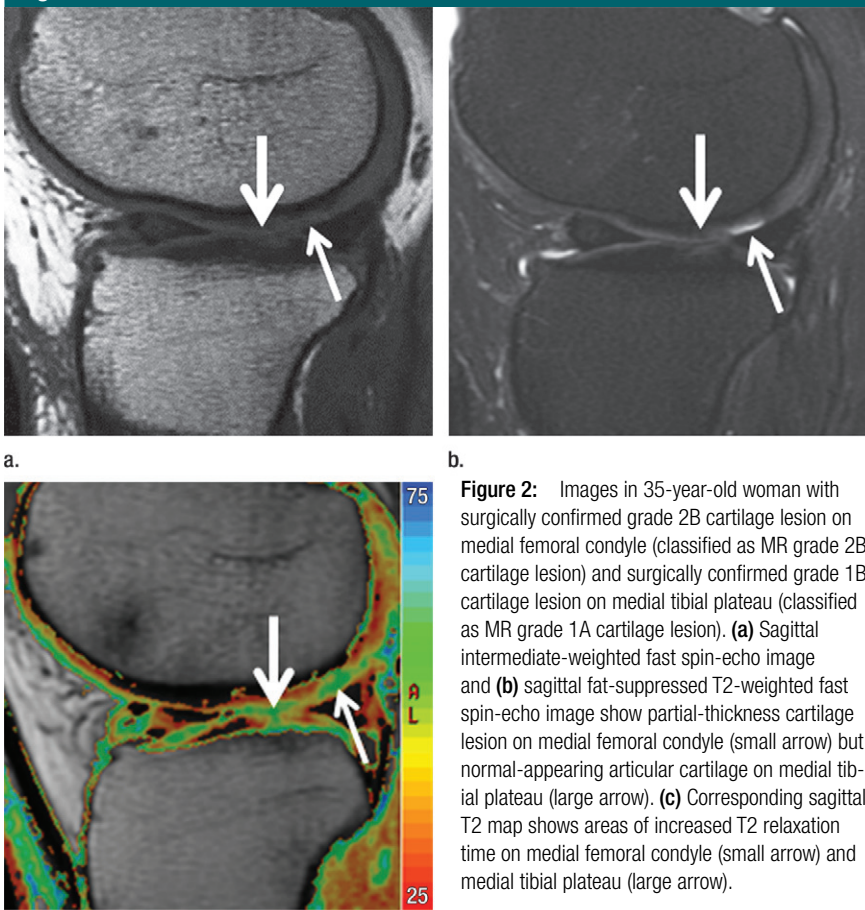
Images in 35-year-old woman with surgically confirmed grade 2B cartilage lesion on medial femoral condyle (classified as MR grade 2B cartilage lesion) and surgically confirmed grade 1B cartilage lesion on medial tibial plateau (classified as MR grade 1A cartilage lesion). (a) Sagittal intermediate-weighted fast spin-echo image and (b) sagittal fat-suppressed T2-weighted fast spin-echo image show partial-thickness cartilage lesion on medial femoral condyle (small arrow) but normal-appearing articular cartilage on medial tibial plateau (large arrow). (c) Corresponding sagittal T2 map shows areas of increased T2 relaxation time on medial femoral condyle (small arrow) and medial tibial plateau (large arrow).
